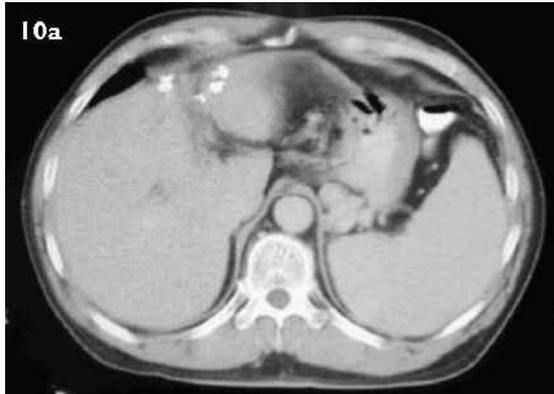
(a) Axial CT image shows hepatic calcification in segments three and four, indicating hepatic involvement in a patient with GI TB. Calcification can be minimal to florid calcification affecting a large part of the liver. (b) Axial CT image shows extensive fatty infiltration in the mesentery and thickened ascending colon in an elderly man who was diagnosed with TB involving the ileocaecum and ascending colon. This patient also had hepatic calcifications. (c) Axial CT image shows mesentery and peritoneal involvements with irregular outline in addition to the presence of ascites.
